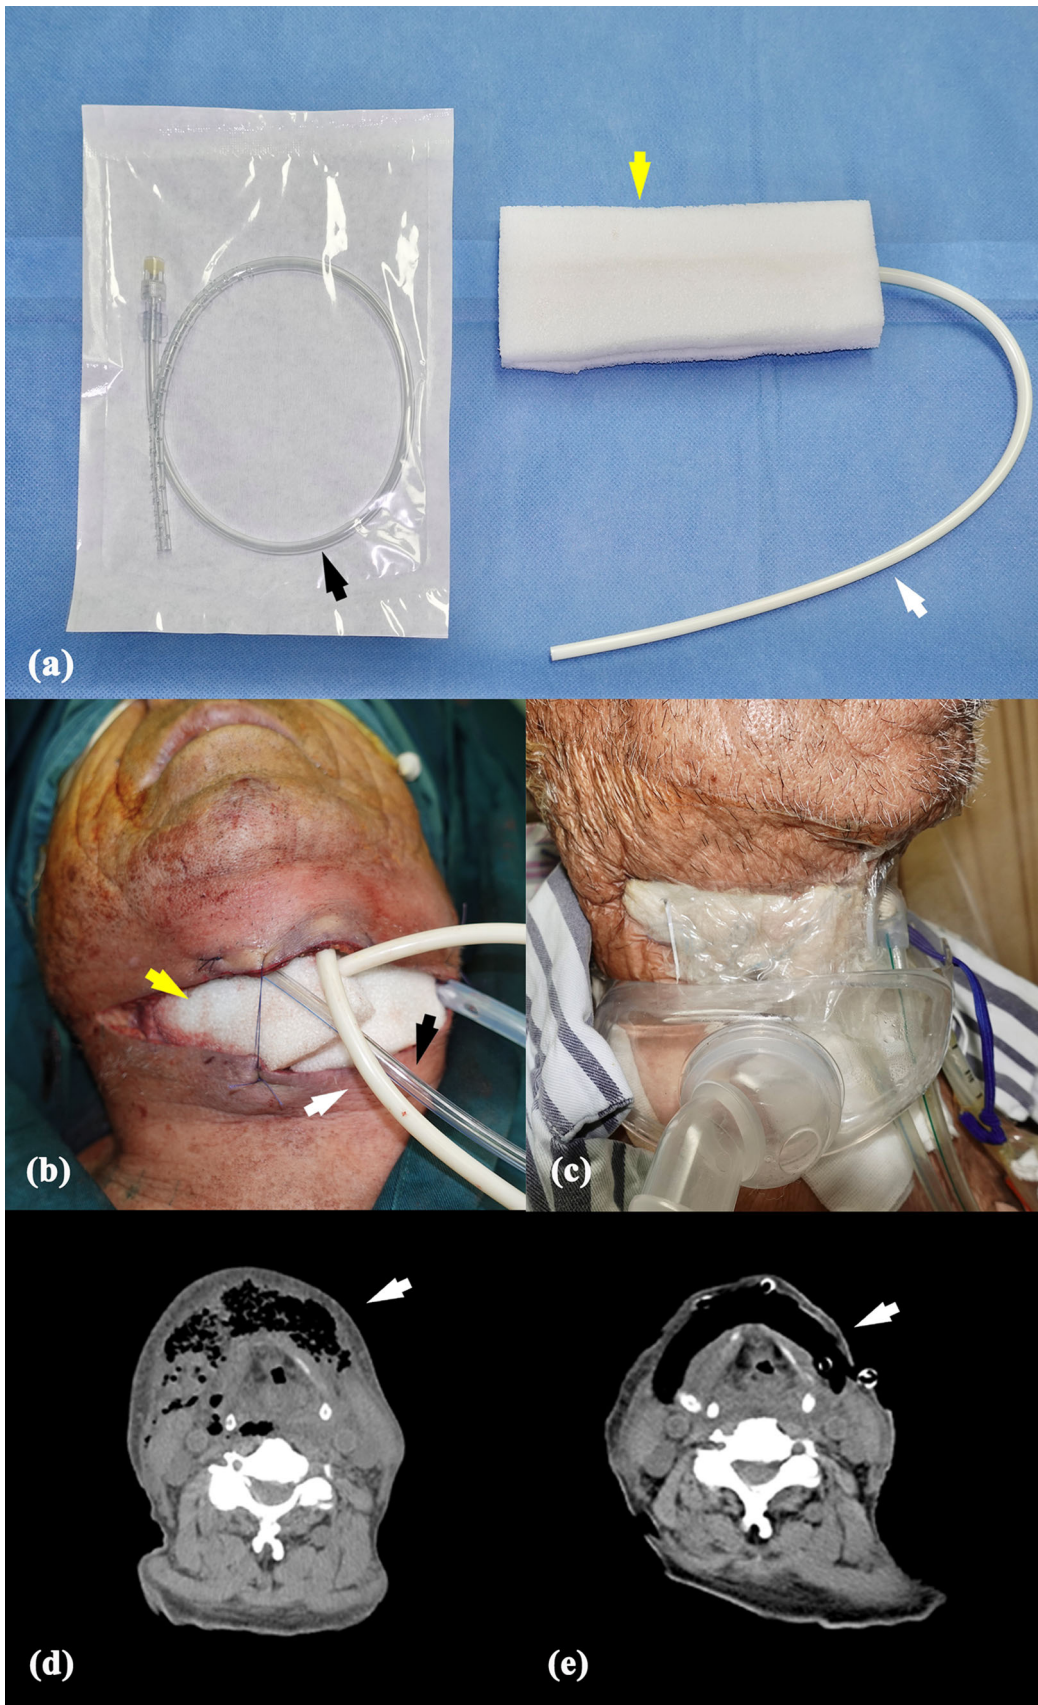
The structure and clinical pictures of vacuum sealing drainage (VSD). (a) The VSD system consisted of the foam dressing (a, the yellow arrow), the drainage tube (a, the white arrow), and the irrigation tube (a, the black arrow). The drainage tube was embedded in the foam dressing. (b) Surgical picture of the placement of VSD including the foam dressing (b, the yellow arrow), the drainage tube (b, the white arrow), and the irrigation tube (b, the black arrow). (c) The whole surgical area was sealed with adhesive films. (d–e) Contrast-enhanced computed tomography scan showing the abscess cavity (d, the white arrow) and VSD after it was put into the abscess cavity (e, the white arrow)
